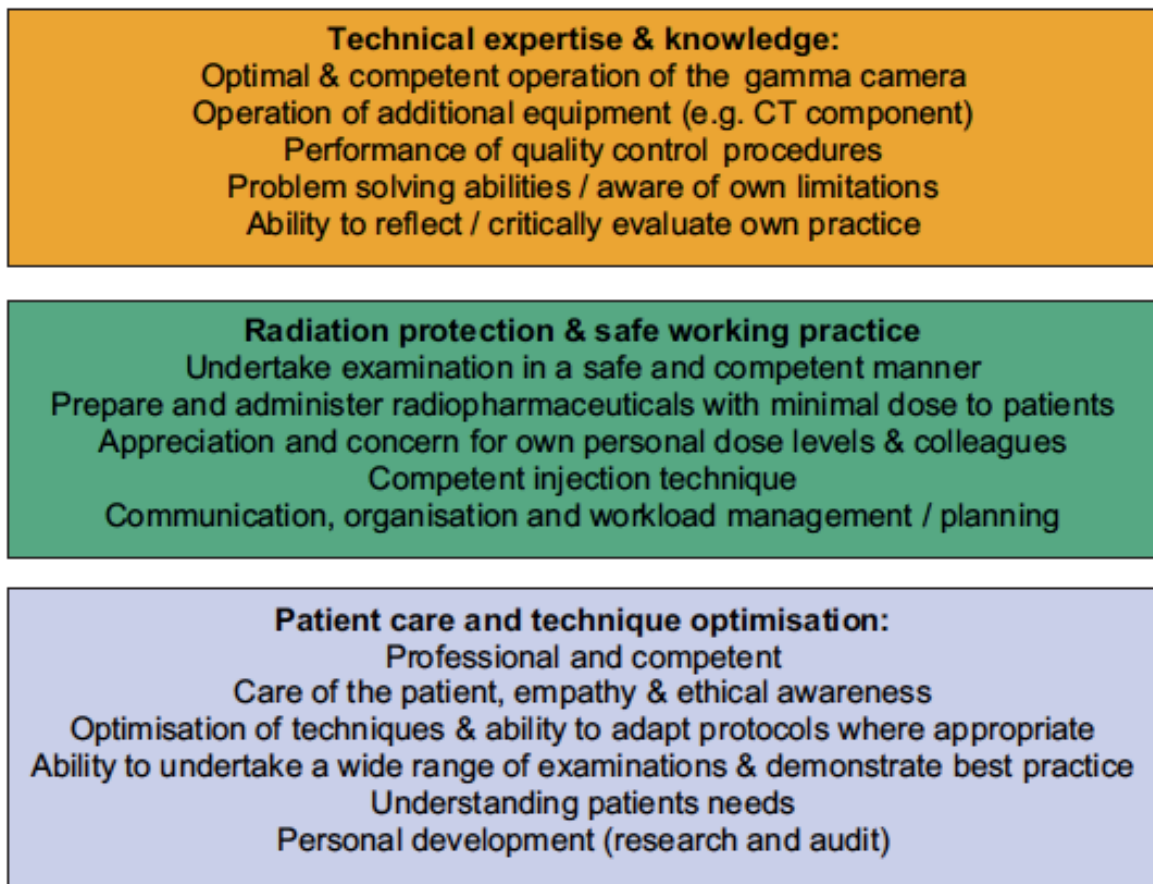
Suggested fundamental qualities of Nuclear Medicine Radiographer.
